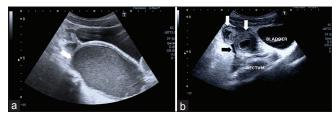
(a and b) Abdominal and pelvic ultrasound. A large cystic mass (white arrows) with echogenic content and thickening of the wall is shown. A small amount of anechoic free fluid is present in the pelvis (black arrow)
